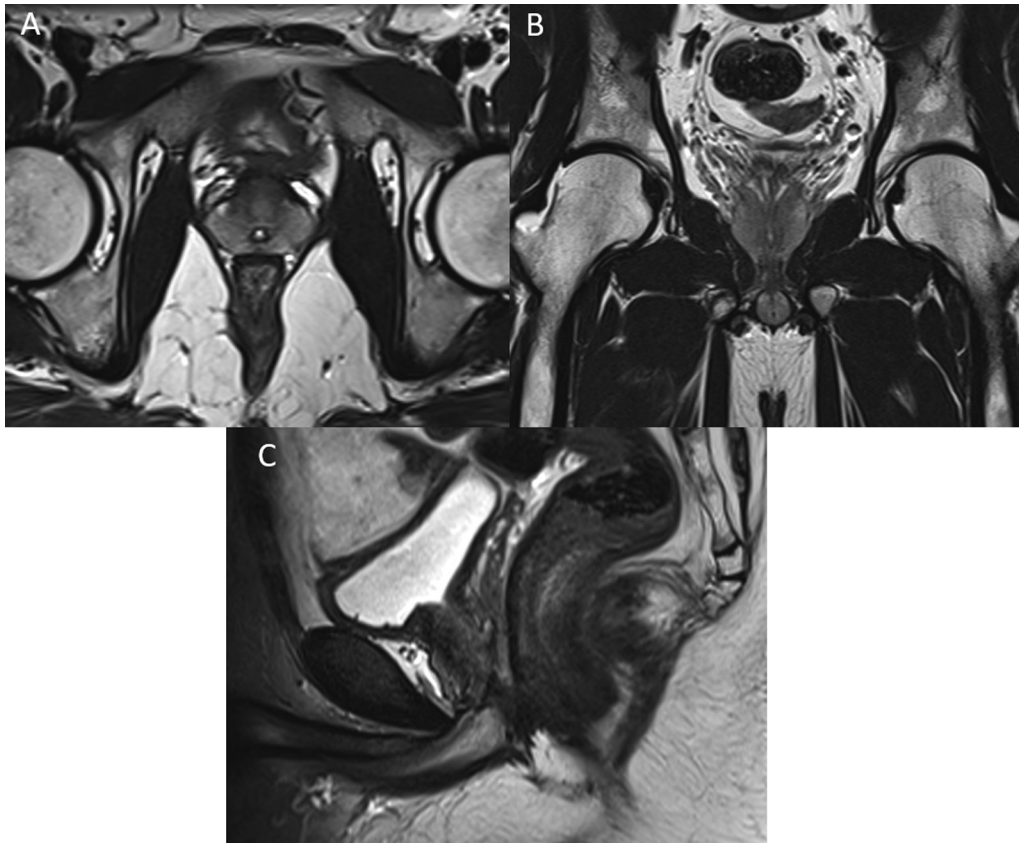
Axial (A), coronal (B) and sagittal (C) T2 MR images showing normal prostate gland in 30 year old man.
